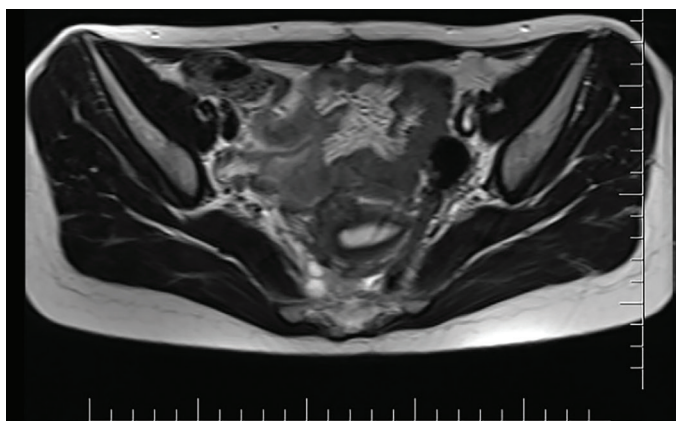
Magnetic resonance imaging image of the uterus after surgery
